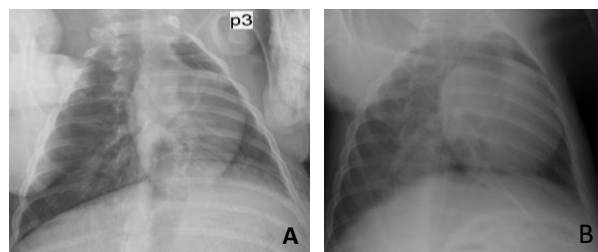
Chest x-ray performed 2 weeks after reconstruction of the diaphragmatic defect with allograft of: a - peritoneum, b - pericardium.
